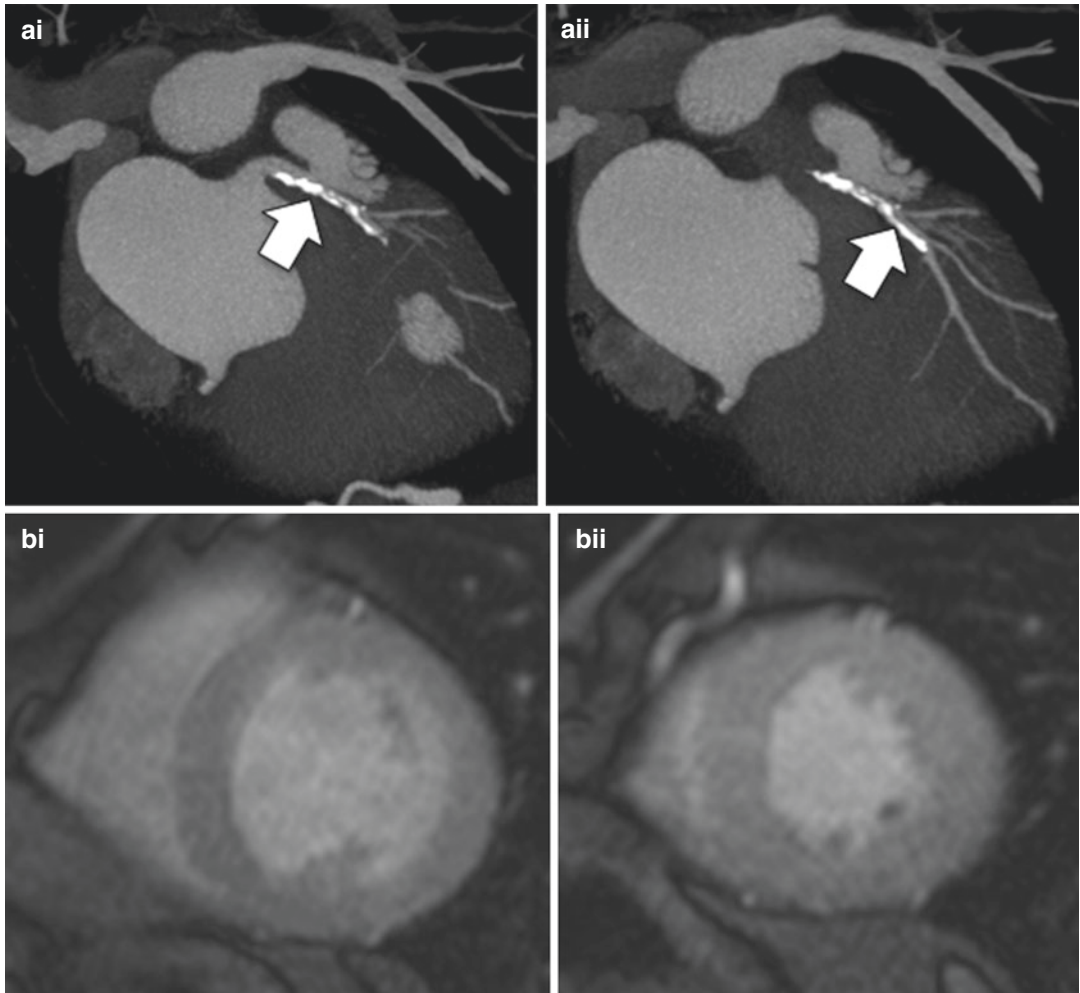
Multimodality coronary imaging in a 35-year-old man with unrepaired coarctation. (ai–ii) Thin-slice maximum intensity projection images from cardiac CT show evidence of severe calcification of the left main and left anterior descending coronary arteries (arrows), raising concern for significant underlying stenosis. (bi–ii) Basal
